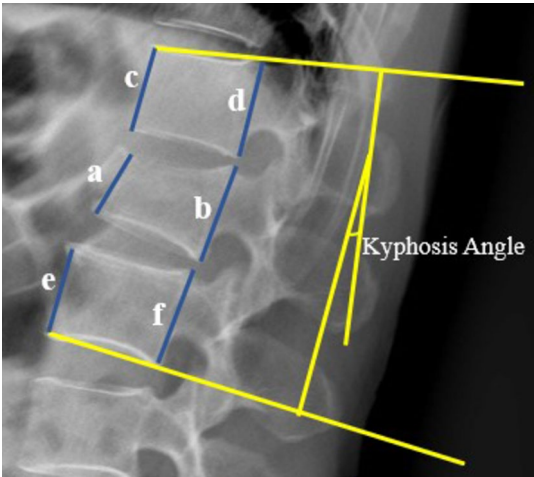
Measurement method for vertebral height loss and kyphosis angle. (1) The kyphosis angle was measured as the angle between the inferior endplate of the vertebra above and the superior endplate of the vertebra below on lateral radiography. (2) a: anterior height of the fractured vertebrae; b: posterior height of the fractured vertebrae; c: anterior height of the cranial vertebrae; d: posterior height of the cranial vertebrae; e: anterior height of the caudal vertebrae; f: posterior height of the caudal vertebrae. Vertebral height
